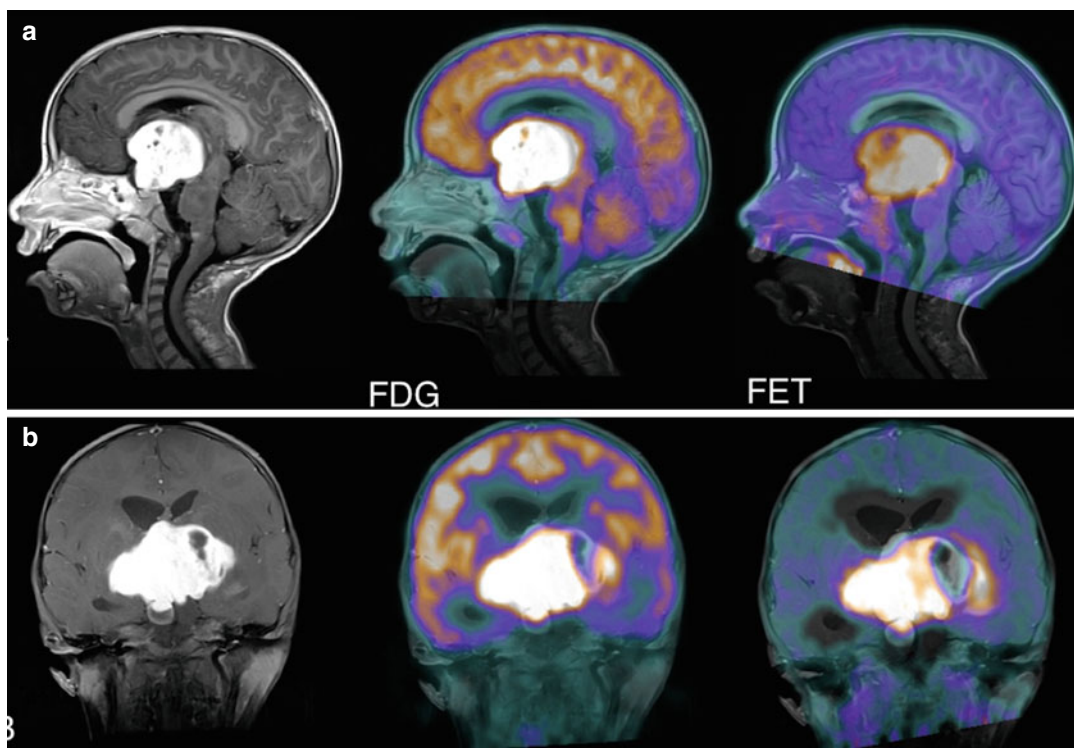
A 3 year-old girl with NF1 presented with weight loss and lethargy. The sagittal (a) and coronal (b) MRI post-gadolinium T1 FLAIR sequences show a large hypothalamic tumor with contrast enhancement. The tumor deviates the brainstem and compresses the pituitary. Fused ^{18}F -FDG (middle) and ^{18}F -FET (right) PET images
